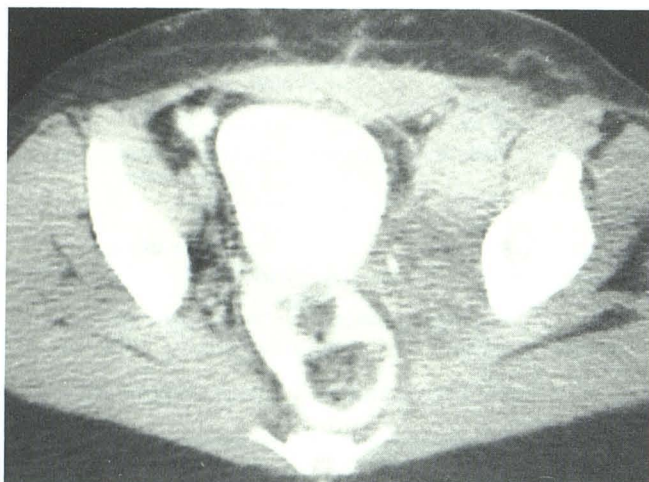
Case 14: left-sided sciatica. After total abdominal hysterectomy and salpingo-oophorectomy for endometrial carcinoma, CT demonstrates metastatic involvement of left iliac lymph node chain extending to left GSF.
